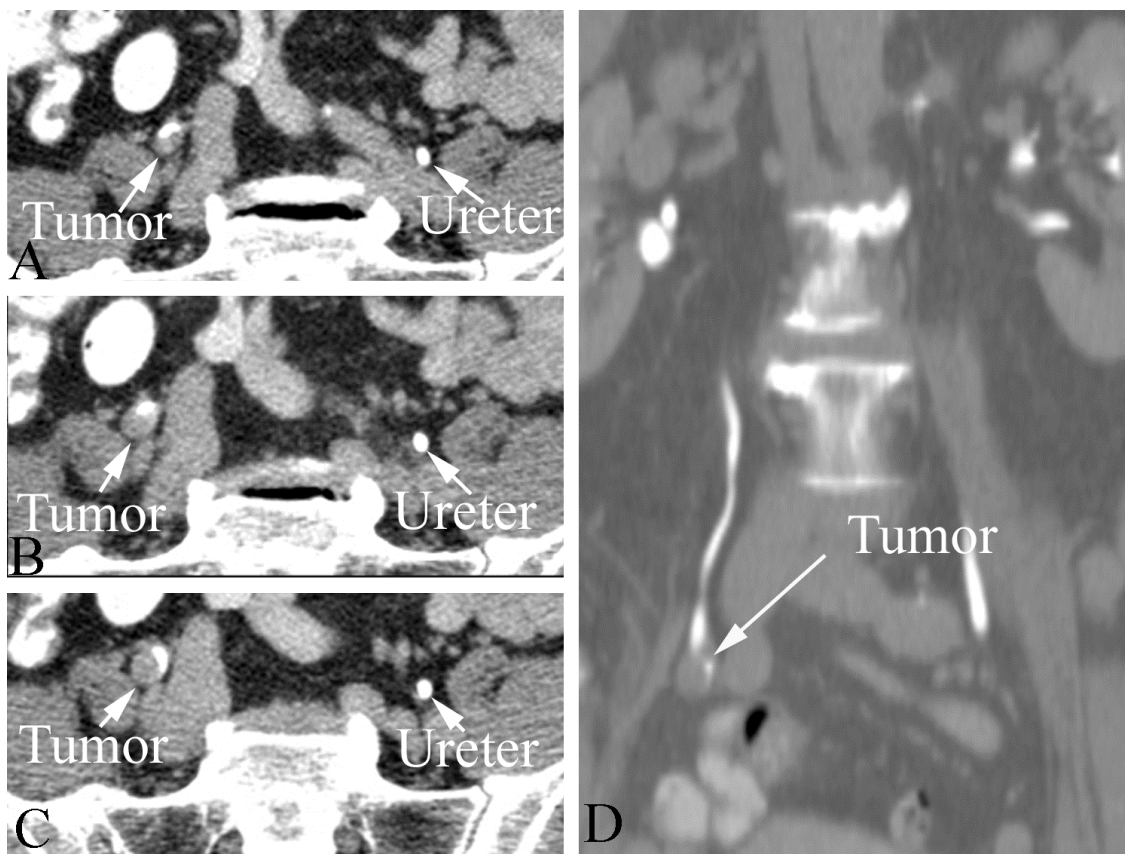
Transitional cell carcinoma of the ureter in a 78 year old man with hematuria. A, B, and C. Sequential axial delayed CT studies show a normal left ureter (in cross section, a small white circle) and an abnormal right ureter with a tumor distorting the ureter, which is peripherally displaced along the tumor margin. D. Delayed reformatted coronal CT shows the tumor (arrow) along the lower margin of the visualized right ureter.
